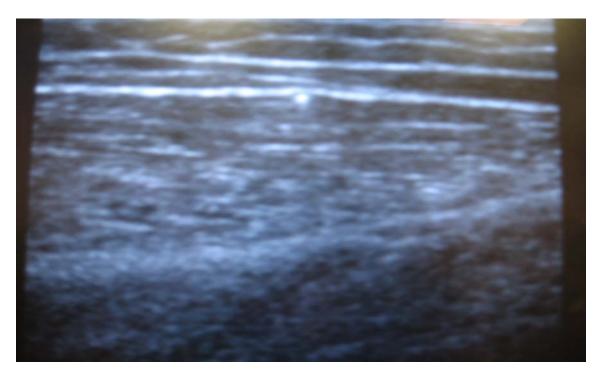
Figure B 5. Doppler Ultrasound Image of Microdialysis Probe_
